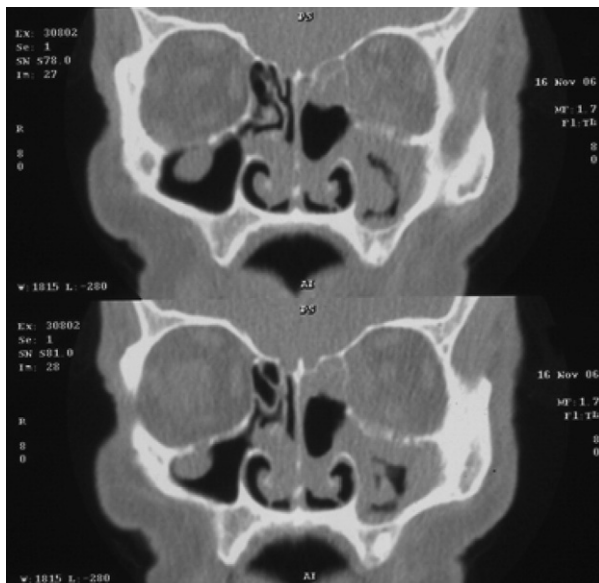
Paranasal sinus CT in coronal plain; diffuse soft tissue obliterating left maxillary sinus aeration and bone erosion at inferior orbital wall.
